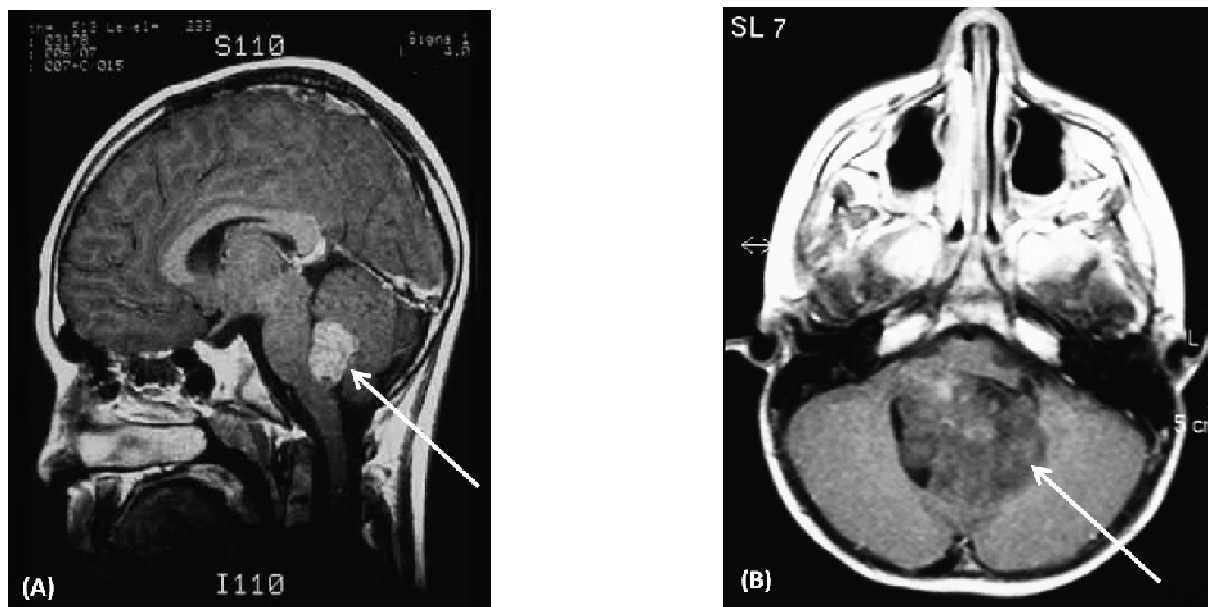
MRI of a children with medulloblastoma (A) Sagittal section of the brain demonstrating tumour in the posterior fossa (B) Axial section of the brain showing a medulloblastoma tumour (Arrows), (Figures taken from www.emedicine.medscape.com/articles).
